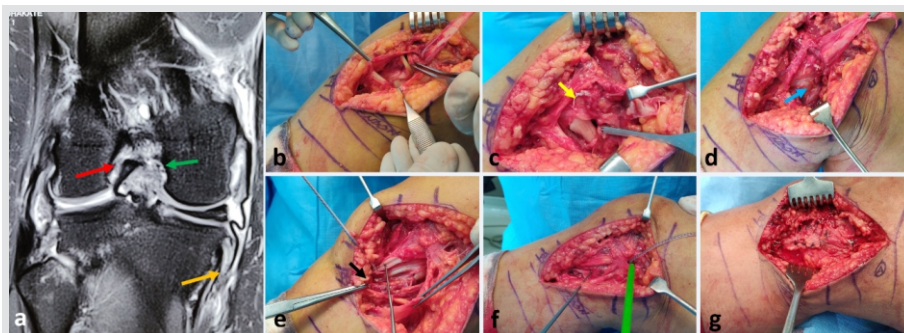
Medial sided repair in a case of KD IIIM dislocation. (a) MRI scan proton density fat-saturated coronal section showing disruption of the ACL (red arrow), PCL (green arrow) and distal MCL (yellow arrow). (b) Complete tear of superficial MCL, deep MCL (meniscotibial fibers) and posterior oblique ligament. (c) The repair proceeds deep to superficial. The deep MCL is repaired first using suture anchors (yellow arrow). (d) The posterior oblique ligament is repaired to its attachment on the tibia using a suture anchor (blue arrow). (e) The superficial MCL is re-attached 6 mm distal to the joint line using another suture anchor (black arrow). (f) Augmentation the repair in this case has been done using synthetic tape and a knotless suture anchor to protect the repair in early rehab. (g) The Sartorius fascia is finally suture back to complete the repair.
